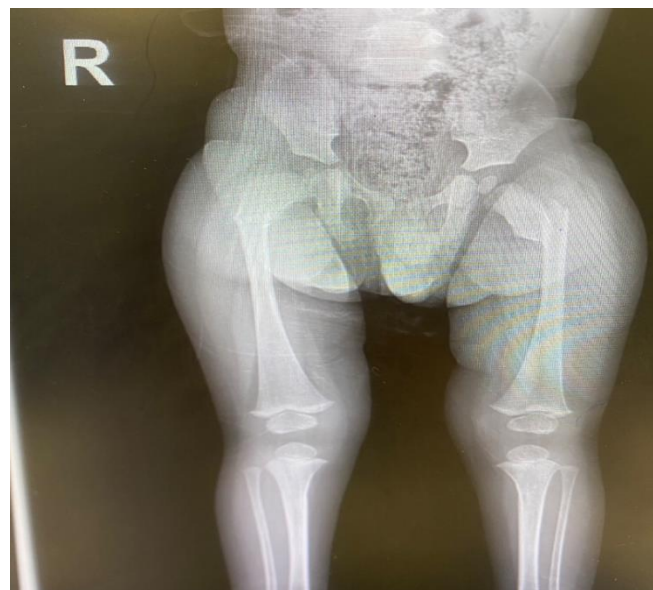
Preoperative radiograph showing bilateral intertrochanteric fractures. (Prepared by Authors, 2026).
